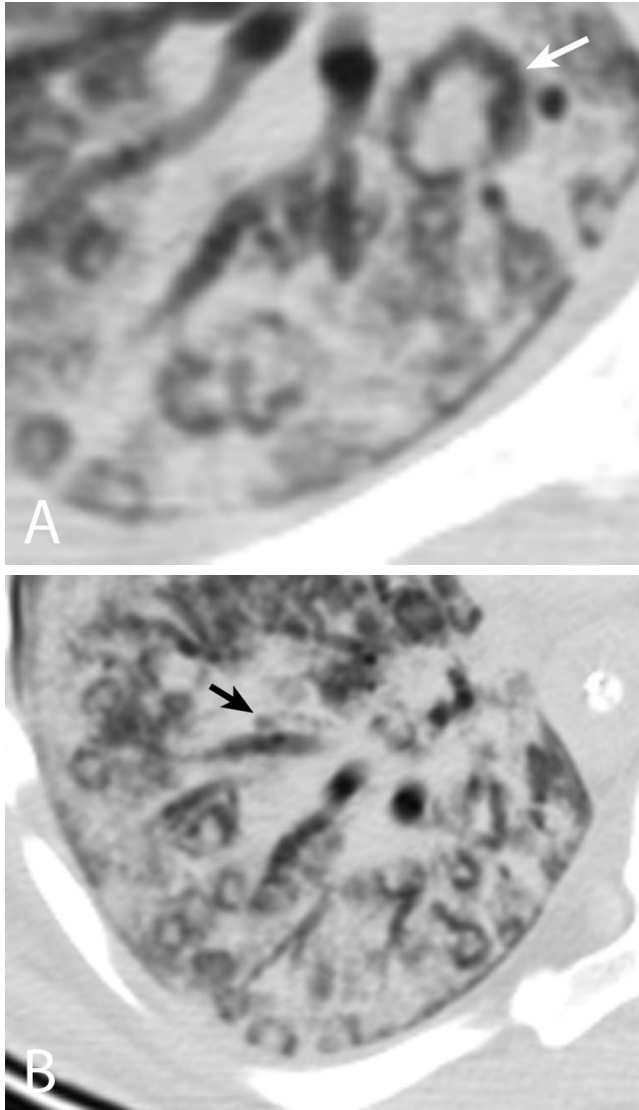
38-year-old male with metastatic choriocarcinoma. A. Coned-down transverse CT image of the lung demonstrates lucent halos surrounding numerous nodules, predominantly seen in the right lower lobe, indicating pulmonary interstitial emphysema. B. A perivascular lucency can also be seen adjacent to a right lower lobe bronchus, also indicating the presence of interstitial gas.
